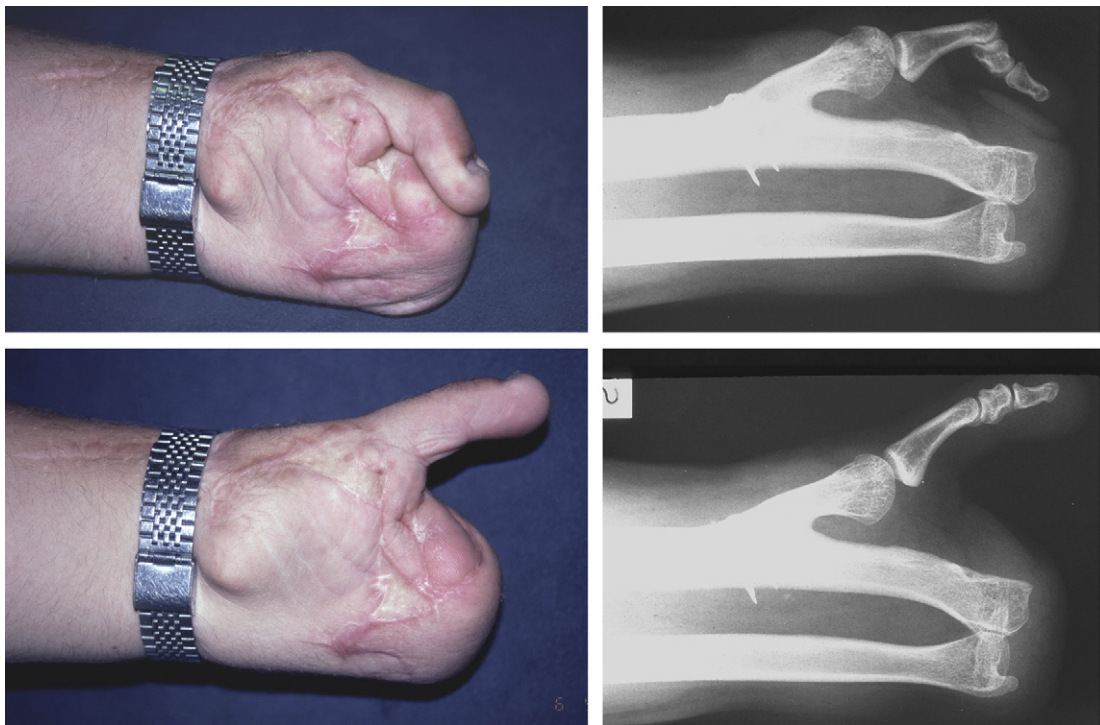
Patient no 8 has a good mobility here shown clinically and radiologically. The X-ray is also showing the typical configuration of the reconstructed thumb. Reproduced with the permission of Elsevier from Textbook: Surgical Techniques in Orthopaedics and Traumatology, Elsevier 2001, Chapter 55-390-B-10; Functional restoration of the no-finger hand.
